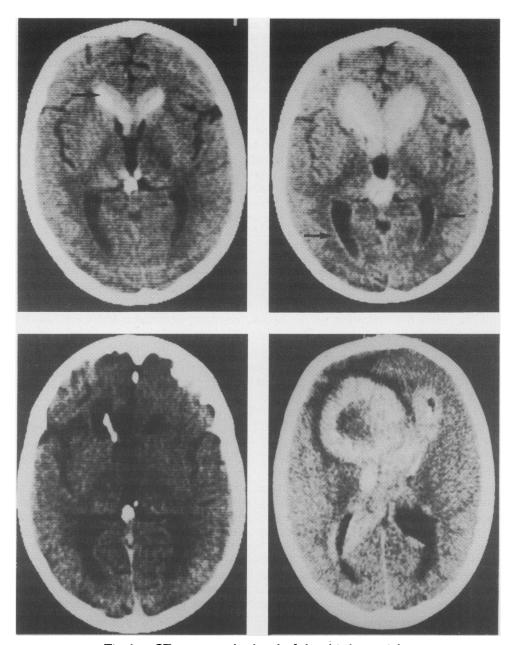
CT scans at the level of the third ventricle.
